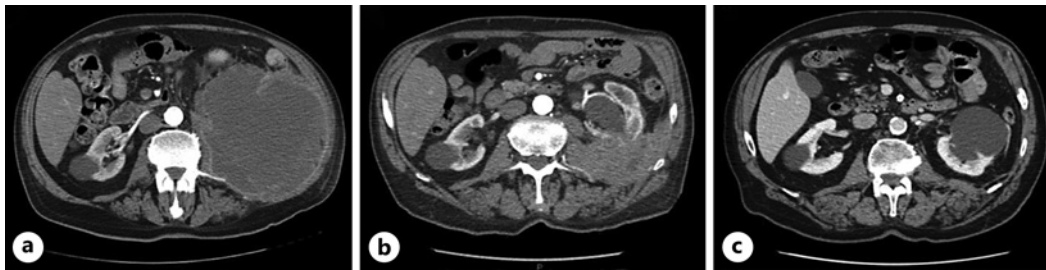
CT scan images of the retroperitoneal mass in size reduction: at diagnosis (a); 4 months from diagnosis (b); approximately 3 years after diagnosis (c).
